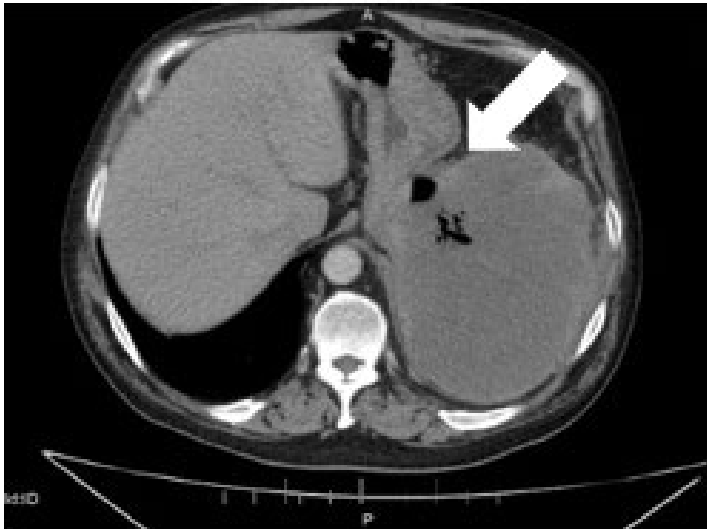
Computed tomography abdomen and pelvis axial view displaying the presence of gas (arrow) within the spleen.
